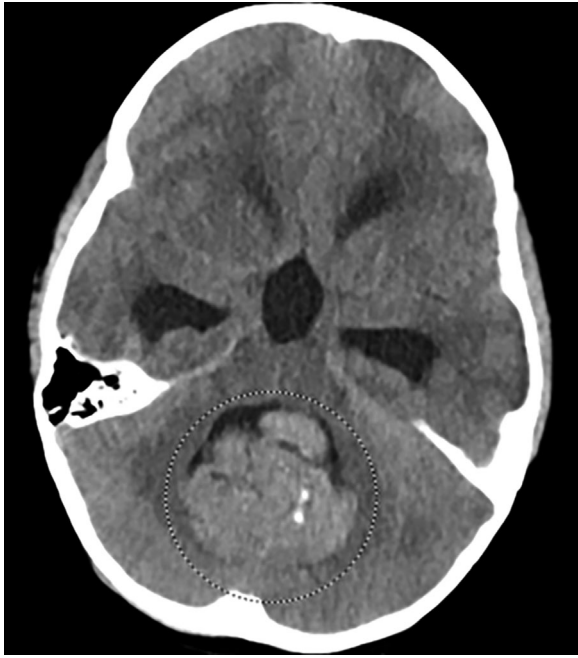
Computed tomography revealing obstructive hydrocephalus secondary to large hyperdense heterogenous 4 cm mass in the fourth ventricle indicating an ependymoma.
